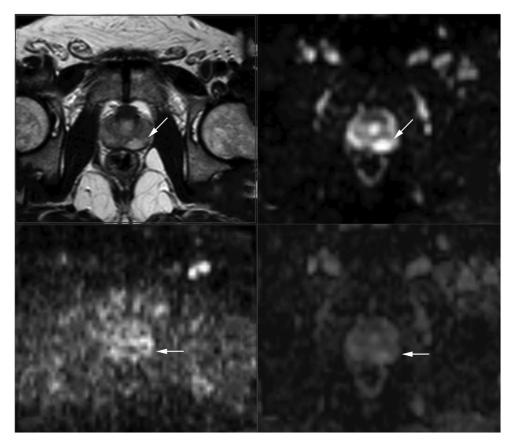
T2 hypointense lesion with mild hyperintensity on high *b*-value DWI images with focal mild hypointensity on ADC in the left lateral peripheral zone (arrows)–PIRADS 3.
